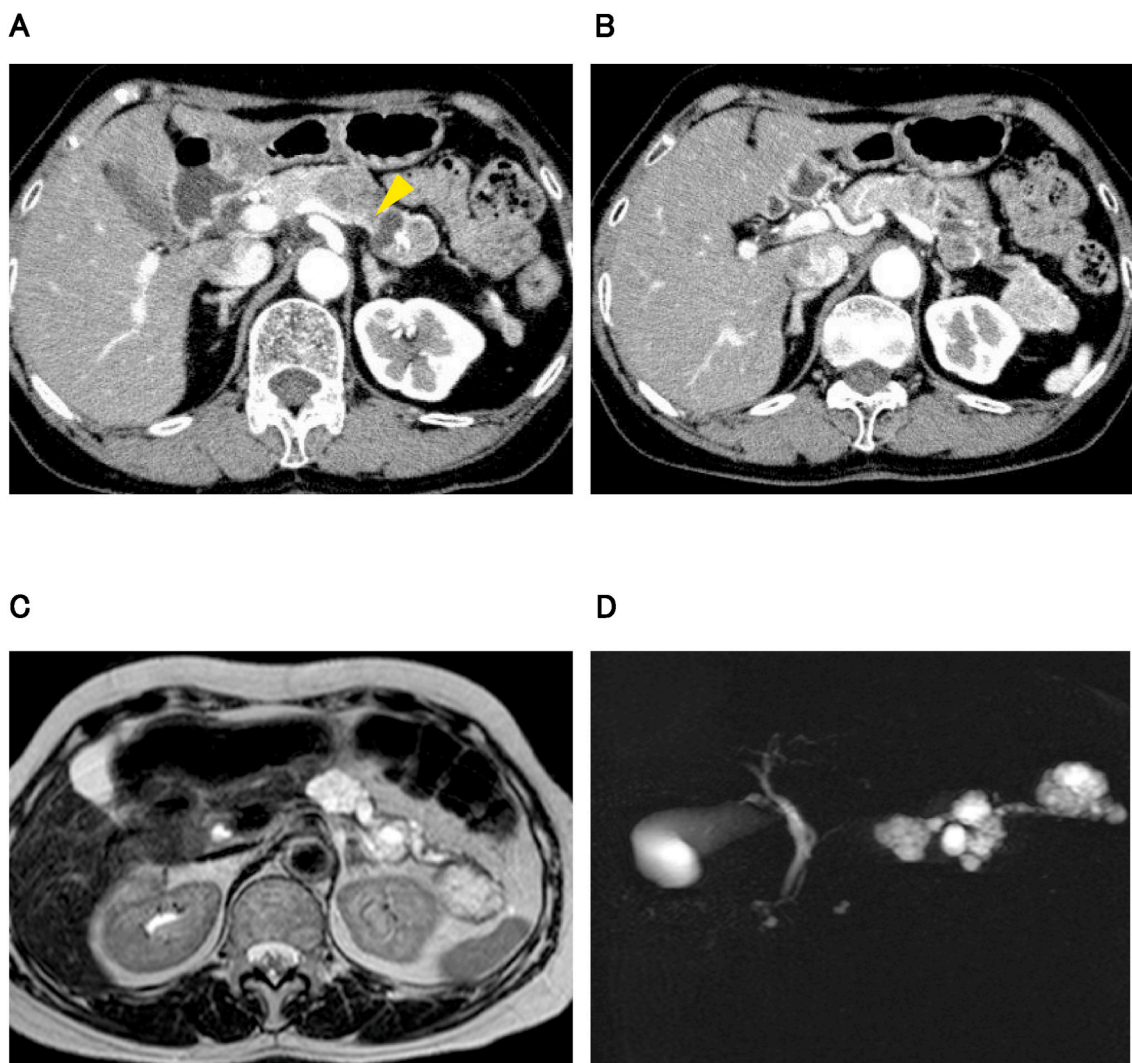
A/B; CT after 2 and a half year
